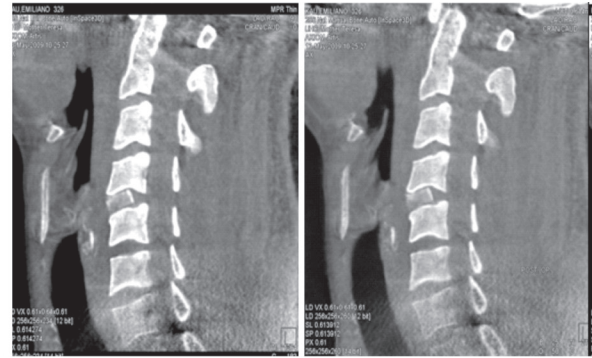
3D radiographs before and after the surgical procedure.
